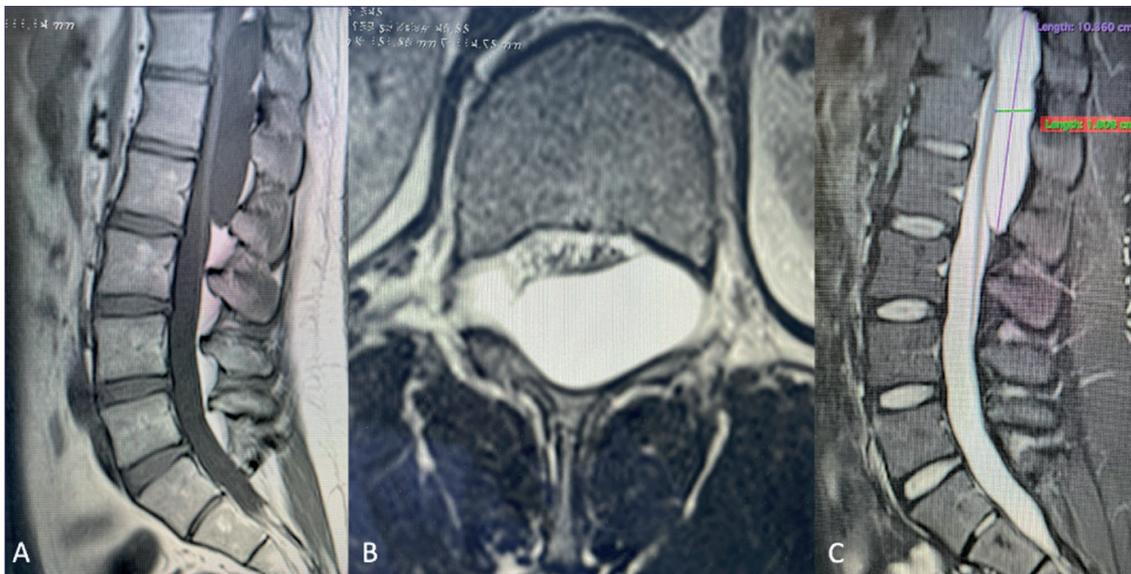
Magnetic Resonance of the Lumbar Spine: A) T1-weighted sagittal section showing a hypointense lesion, cystic in appearance, intraspinal, extradural, extramedullary; B) T2-weighted axial slice, showing ventral compression of the cauda equina; C) T2-powered sagittal section, hyperintense lesion with well-defined borders, measuring 10.3 cm x 1.8 cm.
